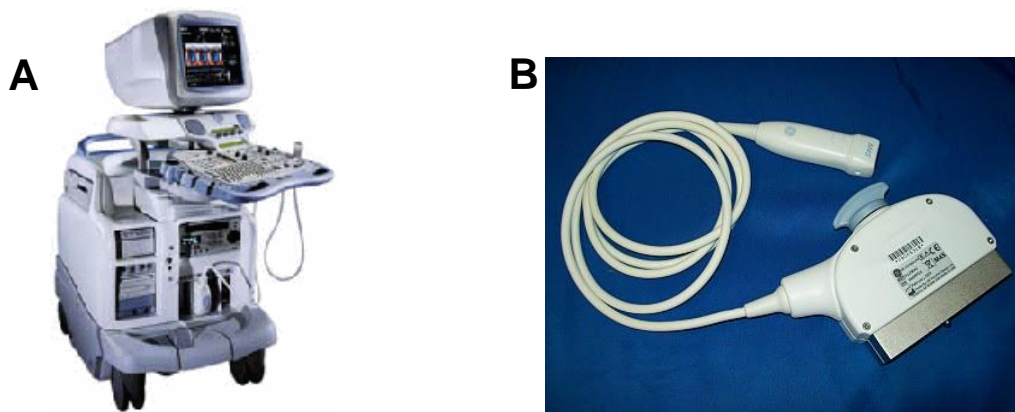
Ultrasound system and probe. Images show (A) Vivid 7 ultrasound and (B) 2-D phased-array M4S transducer (both GE Medical, Horton, Norway) used in all three experimental studies.
